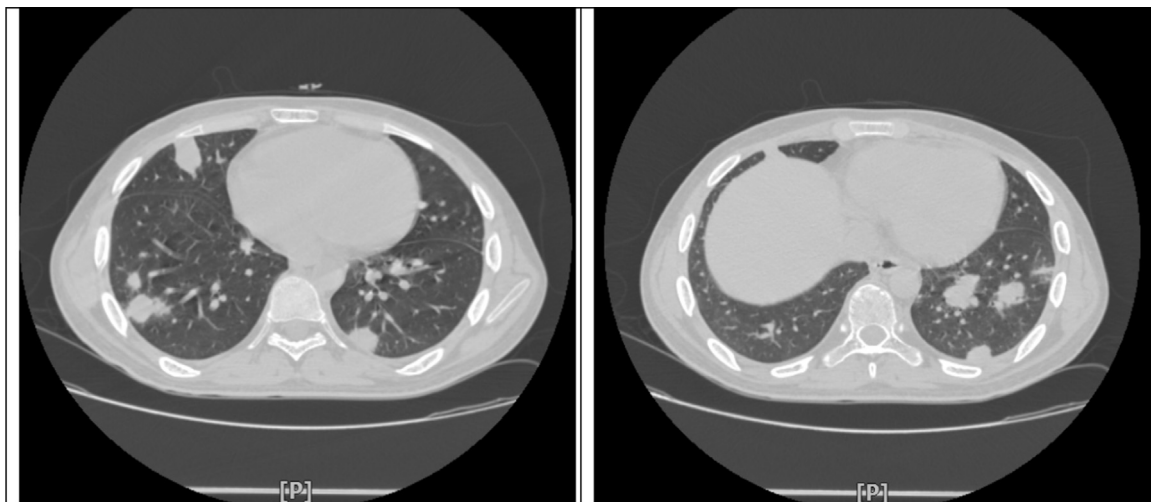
Multiple bilateral round dense ground glass opacities on spiral chest CT scan.
